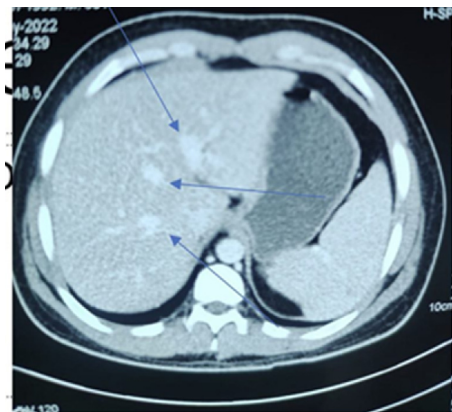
CT abdomen with multiple liver masses.
